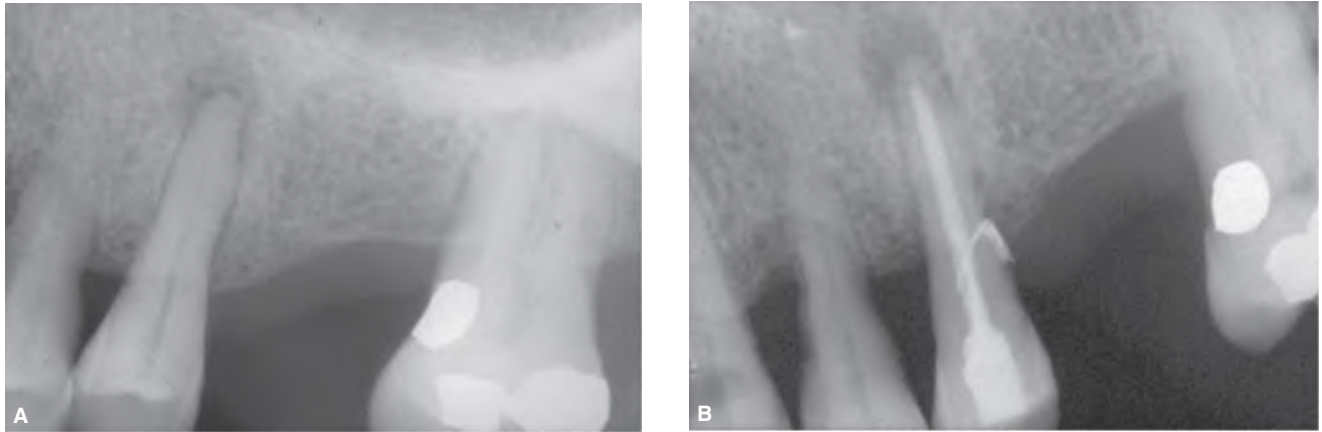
Primary periodontal disease with secondary endodontic involvement in a maxillary premolar. A. Radiograph showing bone loss in one-third of the root and separate periapical radiolucency. The crown was intact, but pulp sensibility tests were negative. B. Radiograph taken immediately after root canal treatment showing sealer in lateral canal that was exposed due to bone loss.
